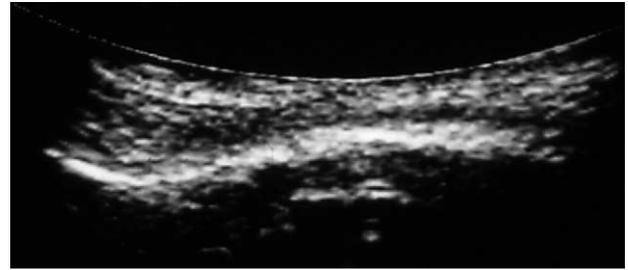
Ultrasound image of an unfractured medial orbital wall. The medial orbital wall shows an s-shaped structure.
